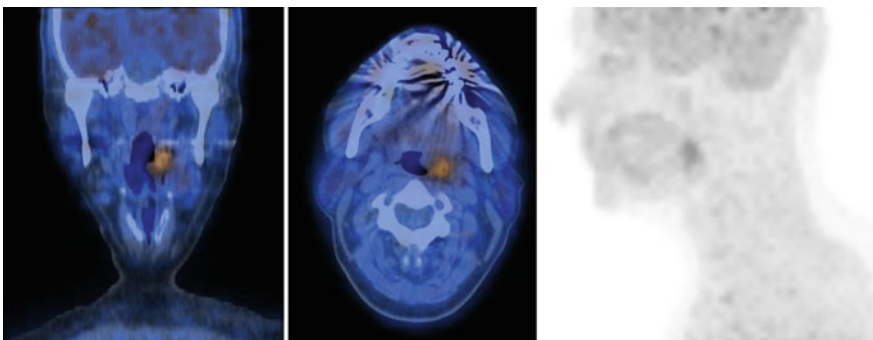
MIP image of ^{64}Cu -ATSM PET/CT (right-sided panel of the figure), with axial and coronal images of a patient with HNSCC referred hypoxia detection
